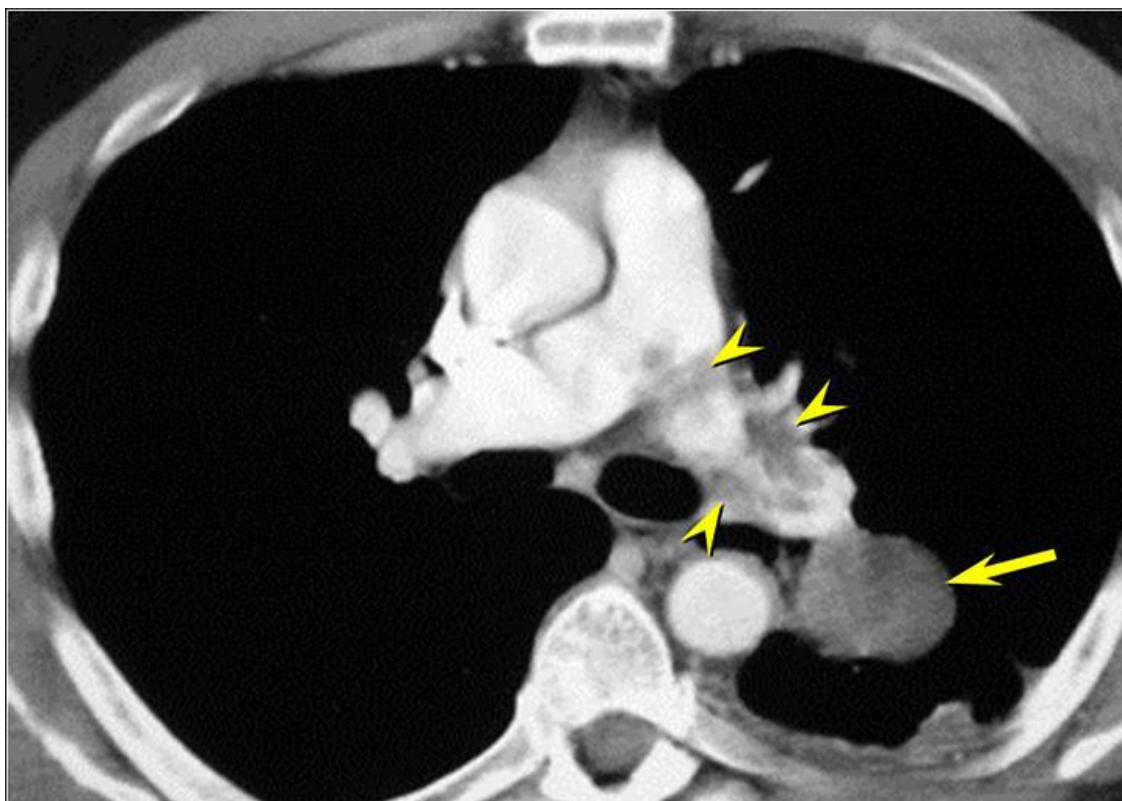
Axial enhanced thoracic CT, obtained as part of a chest, abdomen, and pelvis CT obtained for staging purposes, shows the left perihilar nodule (arrow) is associated with an irregular filling defect (arrowheads) within the left pulmonary artery.
